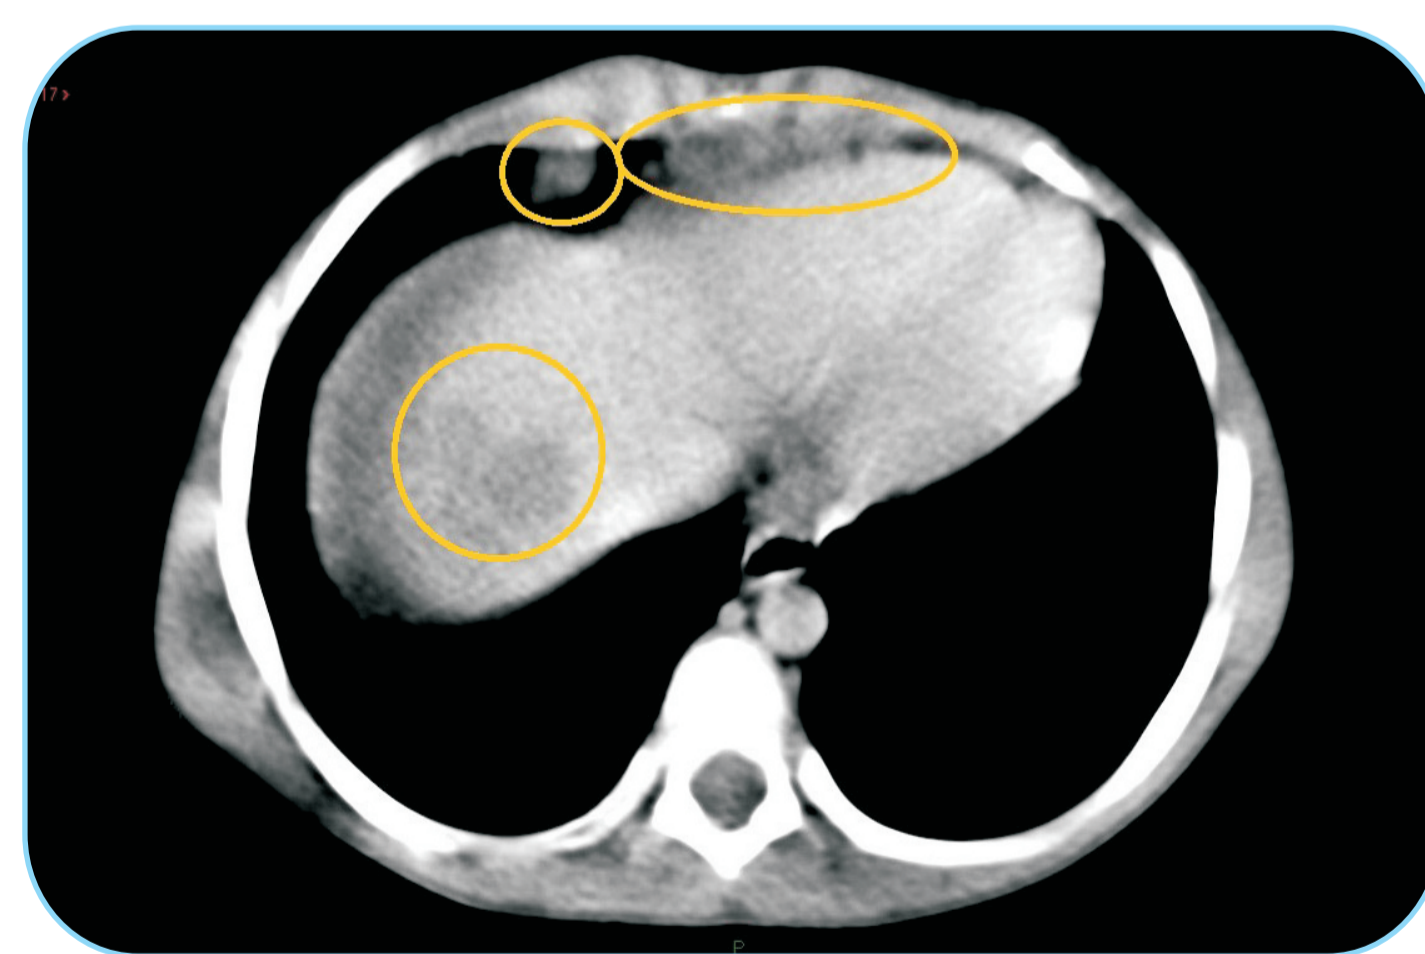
CT abdomen. February, 2015.
